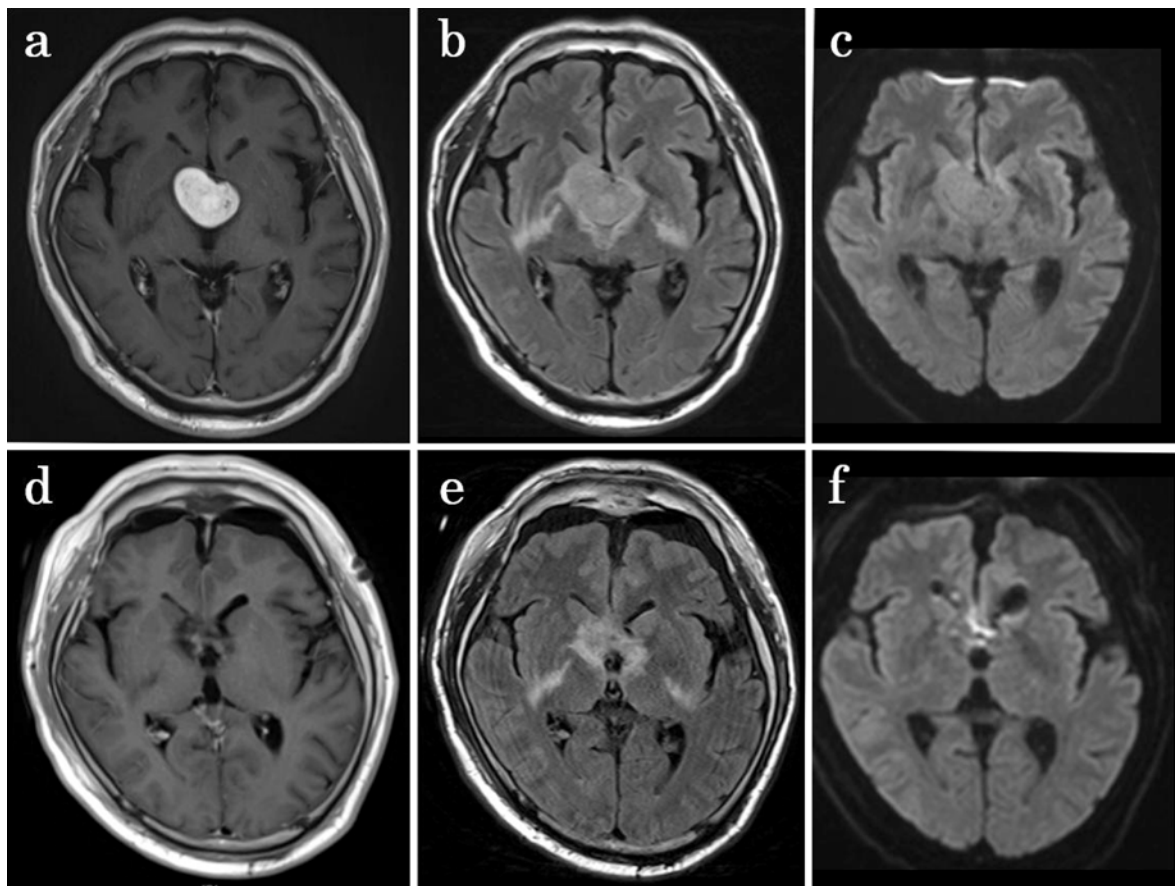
Axial MRI images
